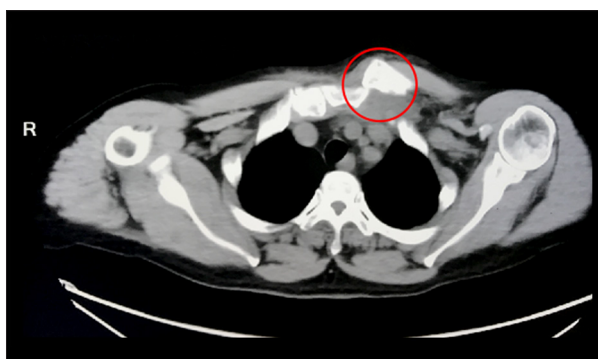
Axial computed tomography image at the initial injury demonstrated the left sternoclavicular dislocation (red circle).
